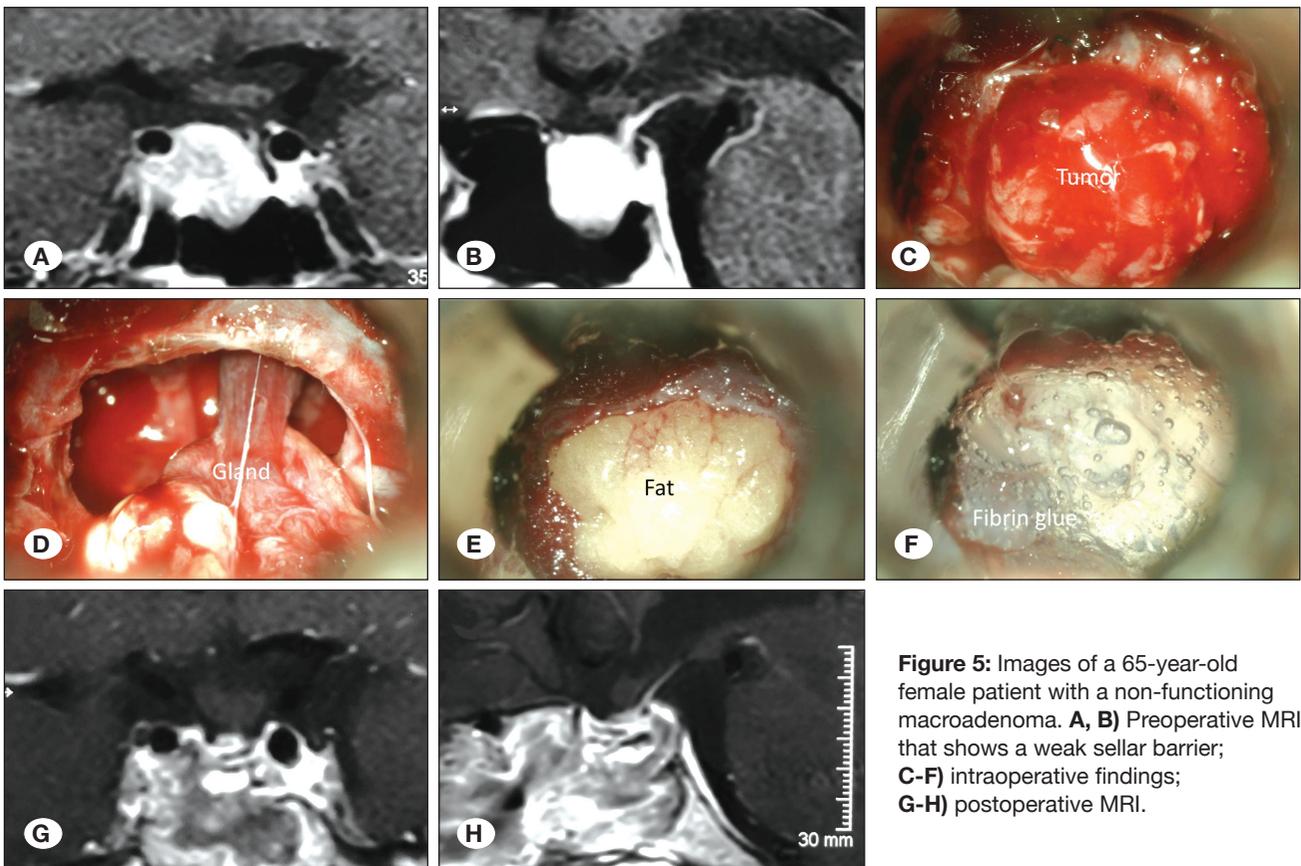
Images of a 65-year-old female patient with a non-functioning macroadenoma. A, B) Preoperative MRI that shows a weak sellar barrier; C-F) intraoperative findings; G-H) postoperative MRI.
